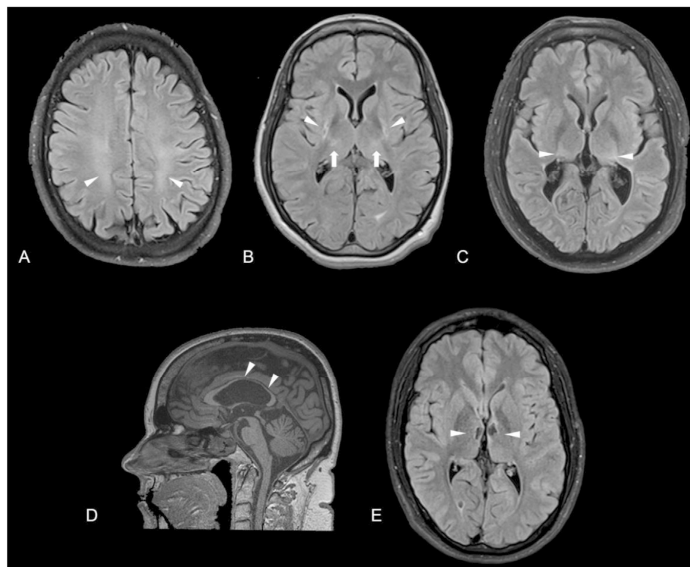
Top row: Axial FLAIR images showing an example of the regions which showed an association with clinical measures. (A) Axial FLAIR: parietal white matter involvement (arrowheads); (B) Axial FLAIR: posterior putamina involvement (arrowheads); here with ventral posterior lateral thalamus involvement (arrows); (C) Axial FLAIR: posterior thalamic involvement (arrowheads); (D) Sagittal T1: thinning of middle and posterior corpus callosum (arrowheads); (E) Axial FLAIR: medial dorsal thalamus involvement (arrowheads). Images correspond to a (A) 50 year old male; (B) 21 year old female; (C) 42 year old male (D) 41 year old female and a (E) 17 year old male.
